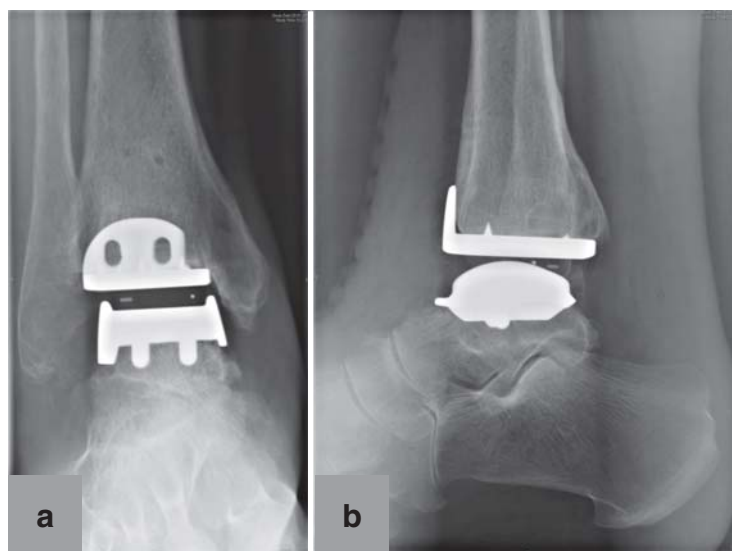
Postoperative X-ray of 67-year-old female patient 6 weeks after total ankle replacement: a) mortise view of ankle; b) lateral view of ankle
